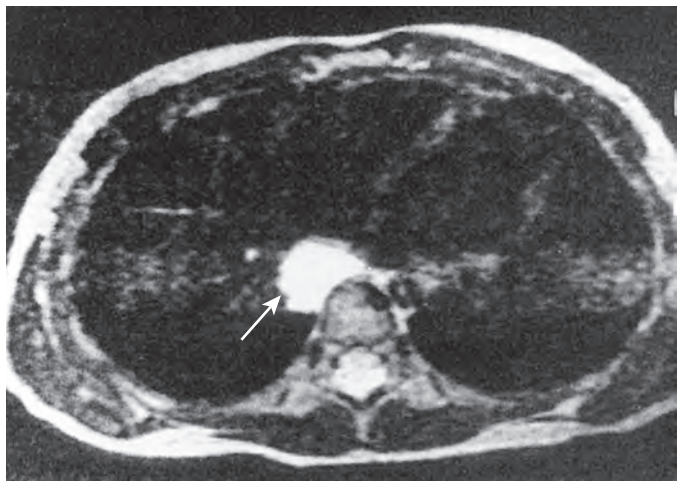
Duplication cyst. Axial T2-weighted MR image shows a fluid-filled, cystic mass (arrow) with high signal intensity in the right side of the mediastinum. (From Rafal RB, Markisz JA: *Magnetic resonance imaging of an esophageal duplication cyst*. *Am J Gastroenterol* 86:1809–1811, 1991.)
